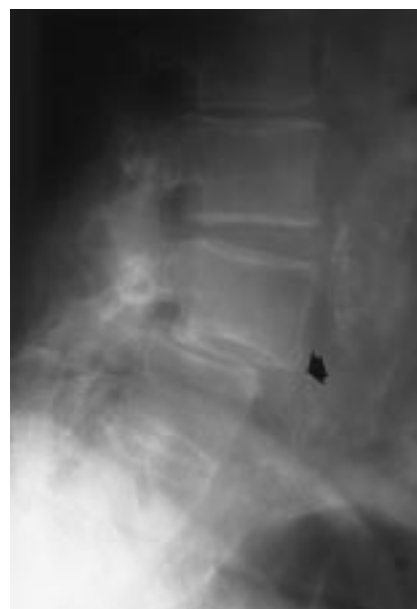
Lateral radiograph of a 70-year-old woman who underwent successful fusion from L-4 to the sacrum 18 years previously. Current presenting symptom was neurologic claudication with pain, localized primarily to the anterior thigh. Displacement of L-3 on L-4 above the solid fusion is demonstrated (arrow).
